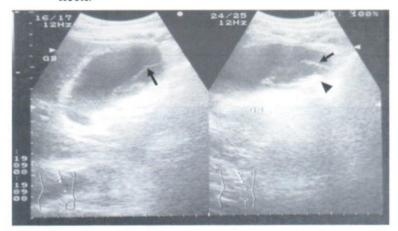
Gangrenous cholecystitis. Ultrasound demonstrates distended gallbladder with intraluminal membrane (arrows). Gallstones (arrowhead) are seen.
